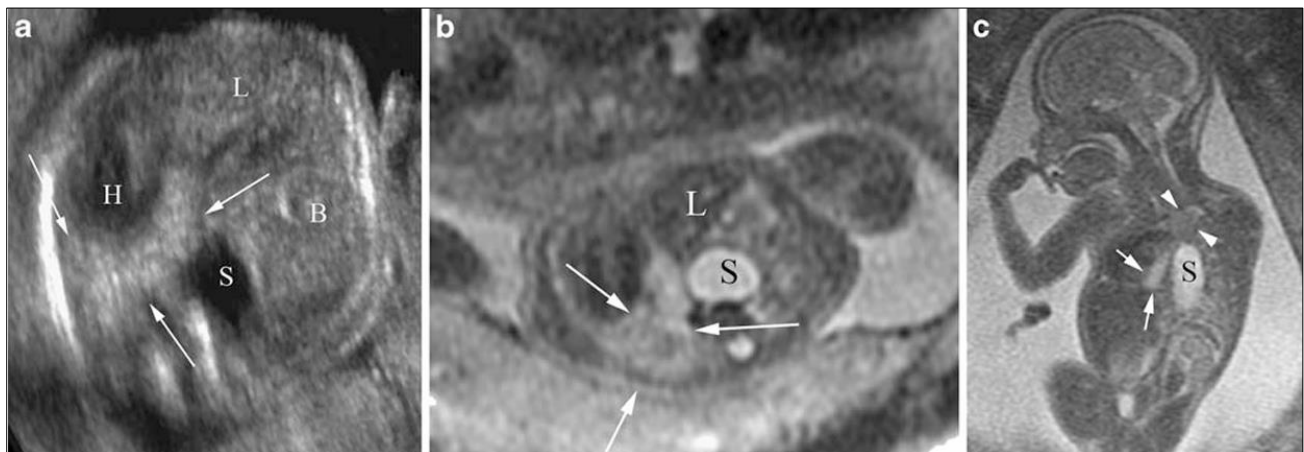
Coexisting left Bochdalek hernia and sequestration in a 22-week fetus. a Axial sonogram of the fetal chest shows herniation of bowel (B), stomach (S), and liver (L) into the fetal chest, with displacement of the heart (H) to the right chest. An echogenic mass (arrows) is interposed between the heart and stomach. a, b Axial (b) and coronal (c) T2-W MR images of the fetus obtained on the same day confirm the presence of a thoracic mass (arrows) with signal intensity higher than that of compressed lung (arrowheads). A left lung sequestration was removed at postnatal repair of a CDH
